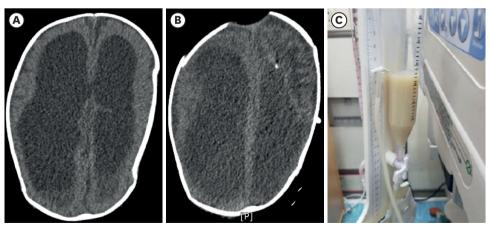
Findings of case 1 patient. (A) Brain CT (HD 5) shows debris in the occipital horns, increased hydrocephalus, and ventriculitis. (B) Brain CT (HD 45) shows multiple septations formed inside the ventricles, both EVDs functioning well without midline shift. (C) The color of the cerebrospinal fluid from the EVD; flow chamber became turbid as the patient developed fever (HD 45). Abbreviations: CT, computed tomography; HD, hospital day; EVD, external ventricular drain.
